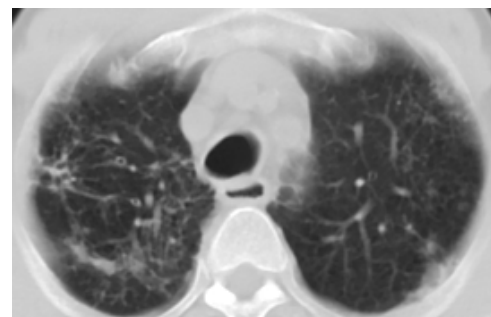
HRCT of 18 years male non-smoker with history of old healed pulmonary tuberculosis shows characteristic right upper lobar interstitial fibrosis.
